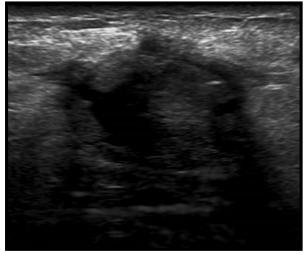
Sonographic appearance of fat necrosis (18).
